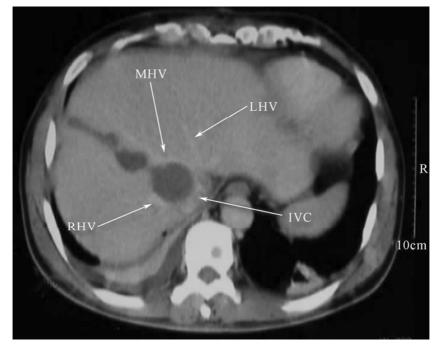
Post operative CT showing the midplane split line and the cavity situated between the LHV, MHV, RHV, and IVC where the caudate lobe was situated
